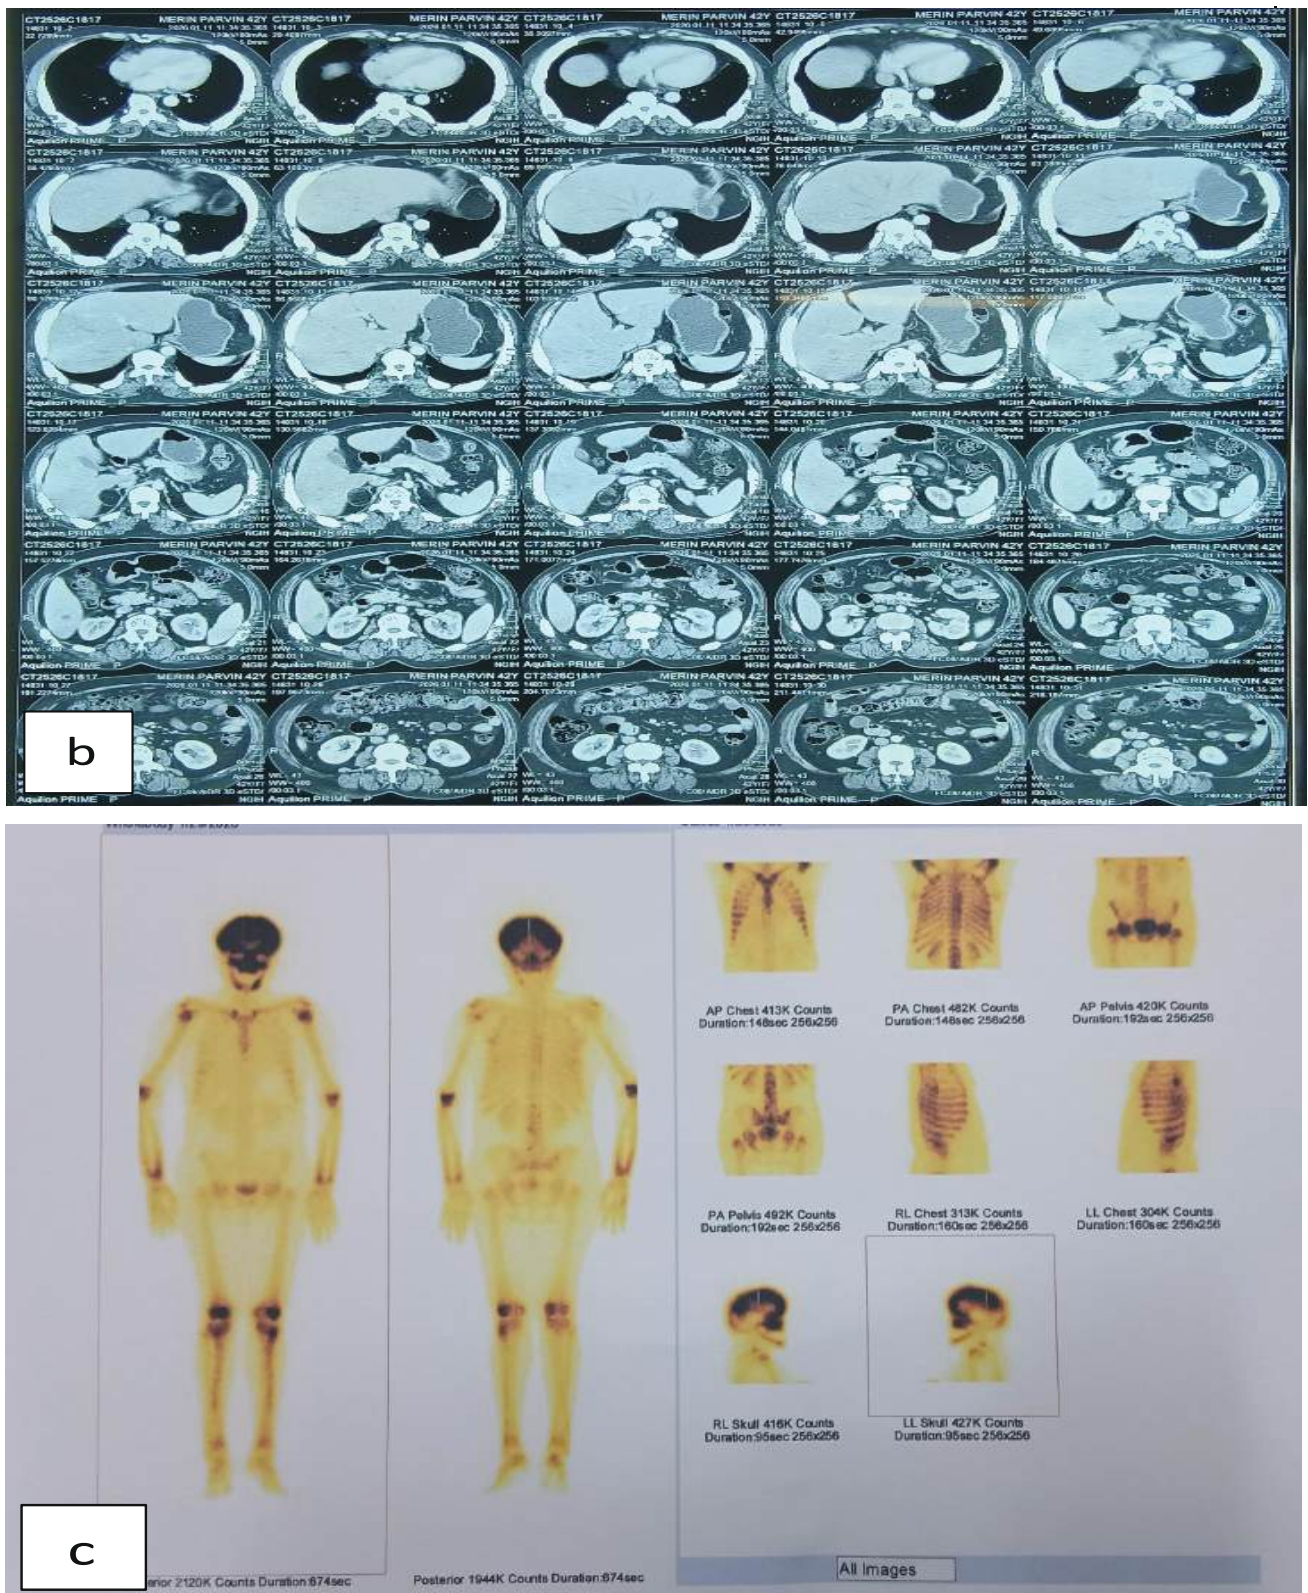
(a) Chest x-ray shows multiple mixed sclerotic and lytic lesion suggesting skeletal metastasis (b) CECT (HBS) shows cortical thickening with multiple osteoblastic deposits in all visible bones suggestive of extensive osteoblastic metastasis, (c) Bone scintigraphy shows nonhomogeneous and diffusely increased radiotracer concentration in appendicular bones suggestive of metabolic bone disease.
